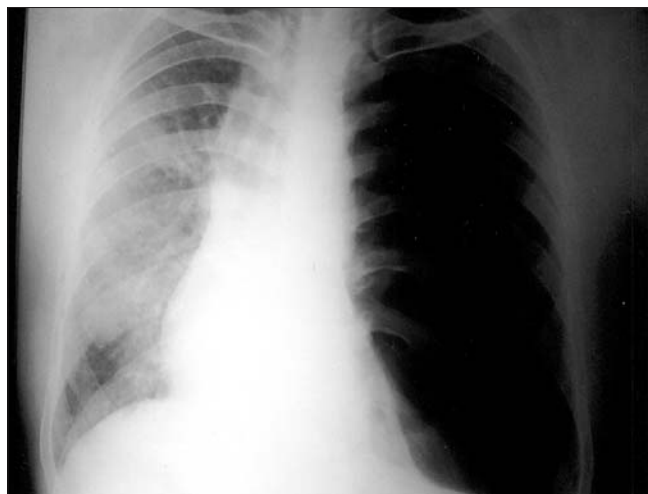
Posterior–anterior chest x-ray.
